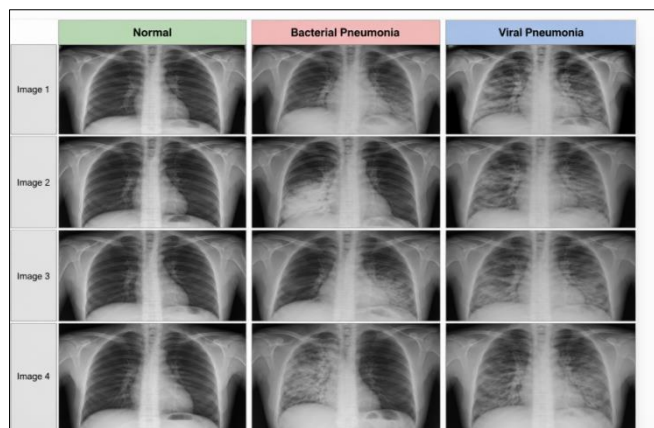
Representative chest X-ray images of Normal, Bacterial Pneumonia, and Viral Pneumonia classes.
